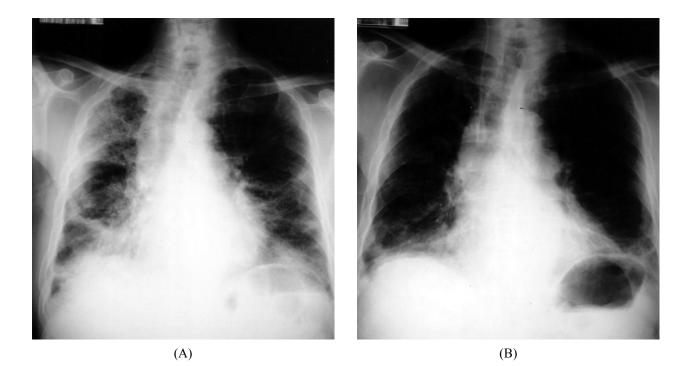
Chest radiographs: (A) initial and (B) after 1 month of treatment with prednisolone.
